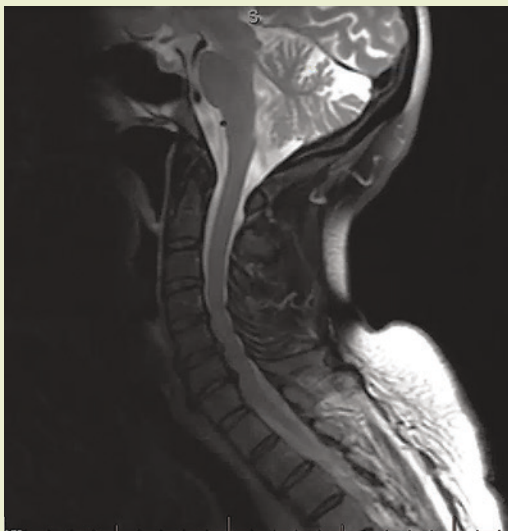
(above): MRI showing C4-7 central canal stenosis.
